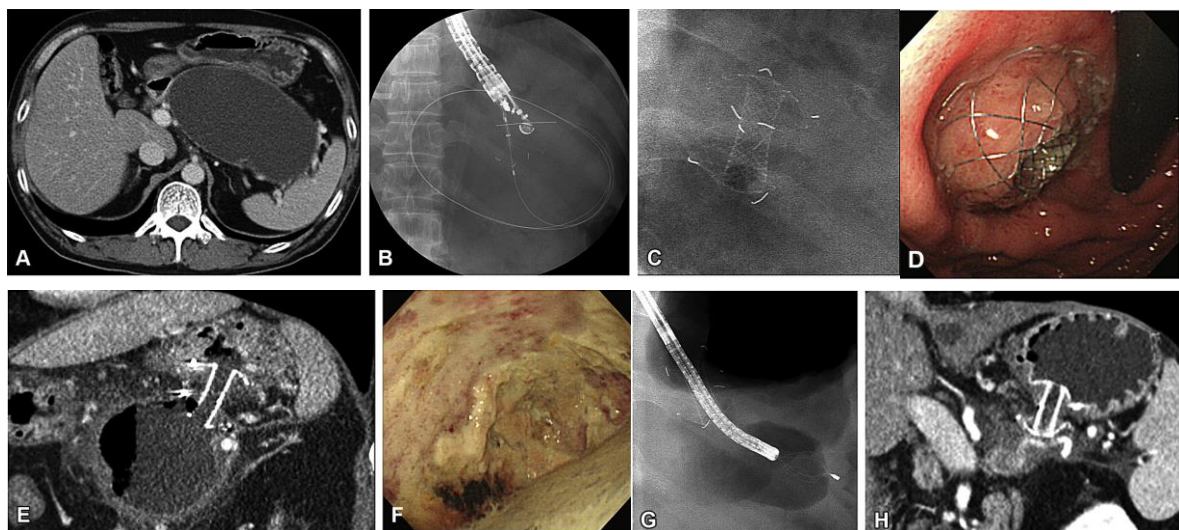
Transgastric EUS-guided pancreatic pseudocyst (PPC) drainage by using the new stent for lumen apposition. A, CT showing PPC. B, Deploying the stent on a PPC. C-E, Fully deployed stent (C, radiograph; D, endoscopy; E, CT). F, Endoscopic view showing the inside of the PPC through the stent. G, Radiograph showing removal of necrotic tissue by using a basket. H, CT showing complete resolution of the PPC by drainage with the stent.
